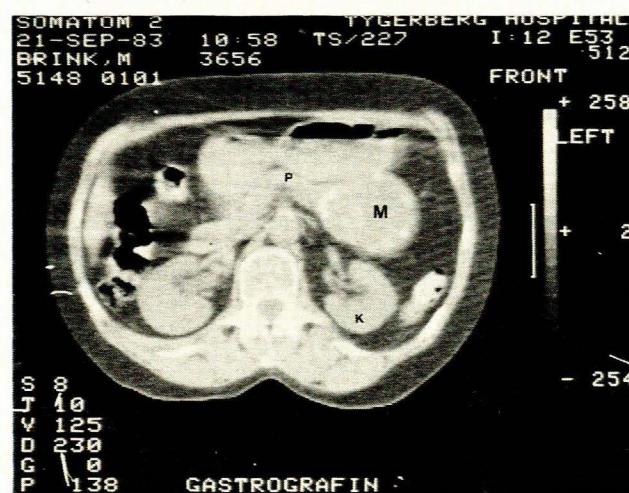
CT scan (M = calcified mass situated in pancreatic tail; P = body of the pancreas; K = left kidney).
